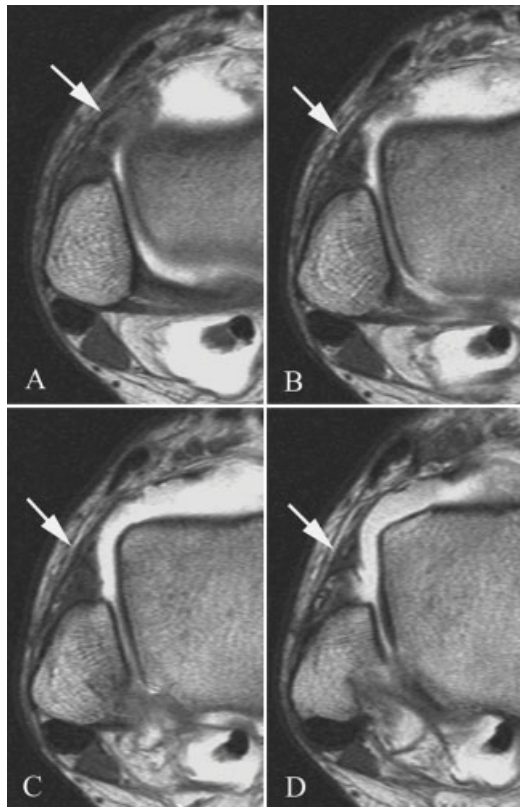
(A–D) Consecutive axial T1-weighted spin-echo magnetic resonance arthrogram performed in a patient with anterolateral impingement syndrome. Images proceeding cranial to caudal through right ankle demonstrate irregular soft tissue thickening in the anterolateral gutter (arrows). (E) Corresponding arthroscopic image demonstrates scarring and synovitis (arrows) in the anterolateral gutter. L, lateral malleolus; T, talus. Reprinted with permission of Dr. Antonio Cruz, Santander, Spain.
